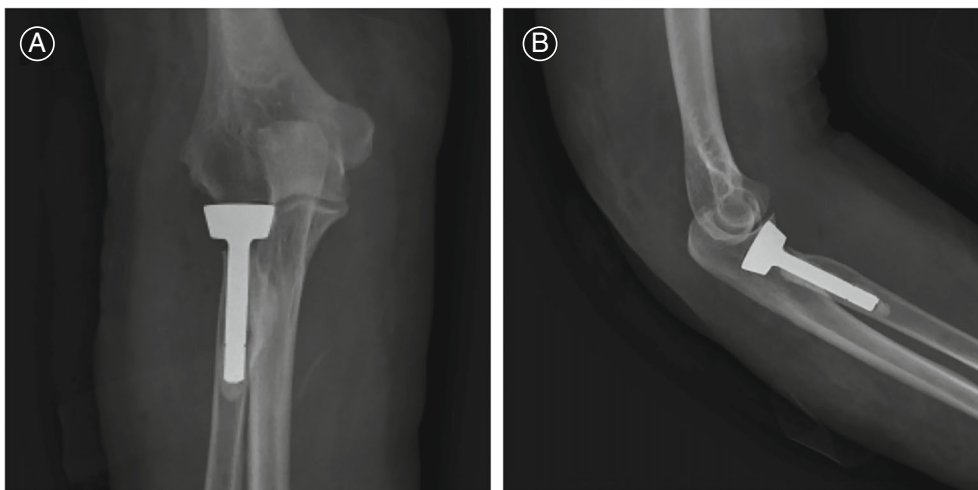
Postoperative anteroposterior (A) and lateral (B) radiographs (radial head prosthesis; Wright Medical Technology, Memphis, TN, USA).
